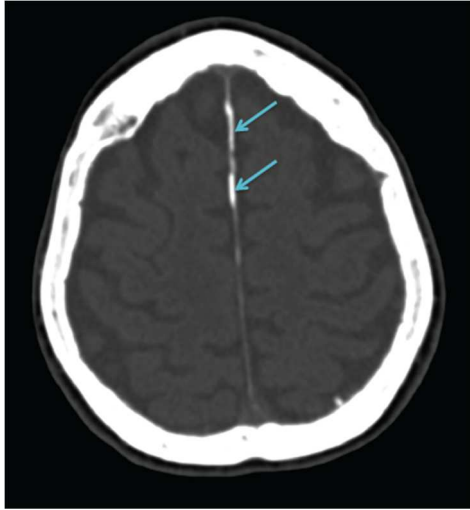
Representative example of a transverse CT-scan image from one participant using vitamin K antagonist, with the falcian calcifications marked by arrows.
